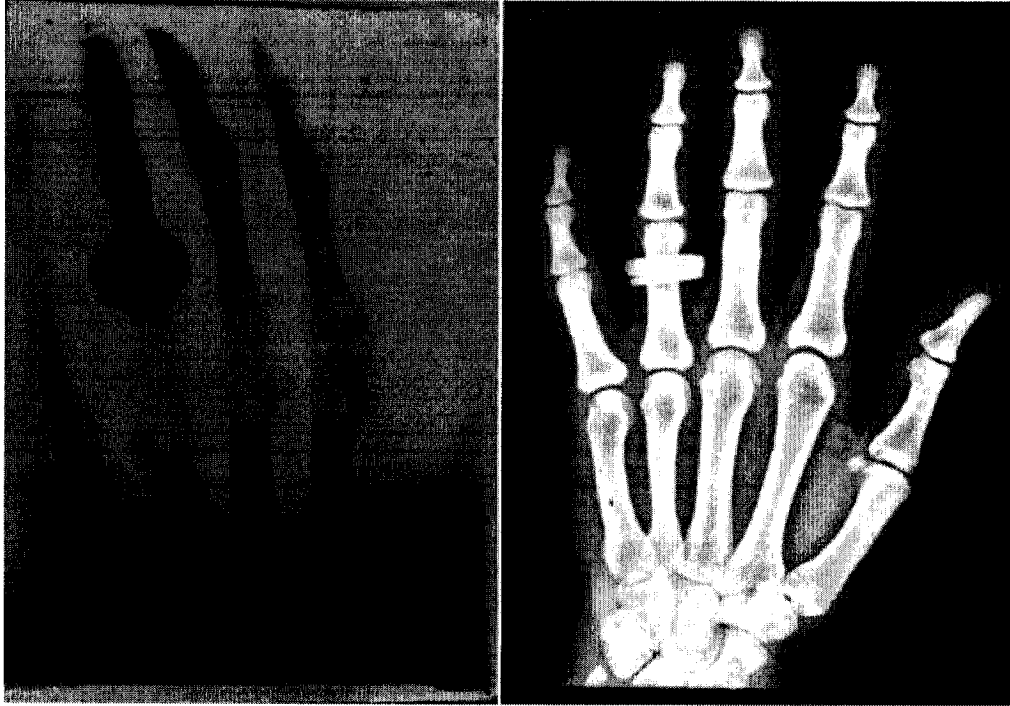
Changes over 100 years [57]. Left : first radiograph taken in year 1895 by W. C. Röntgen. Right: X-ray taken in 1995.
